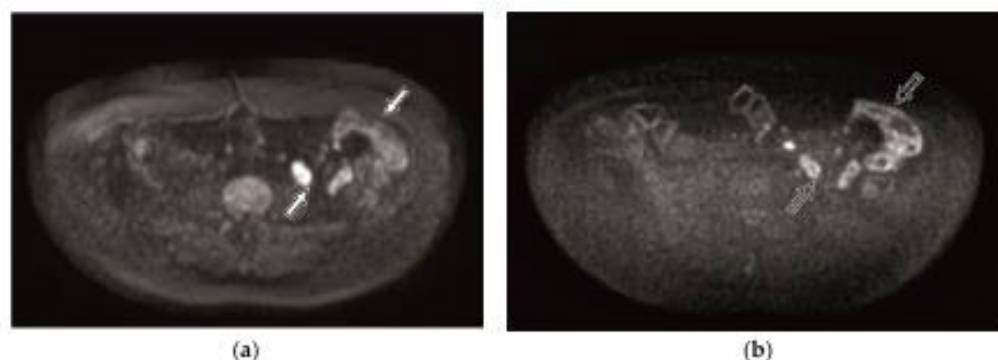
Diffusion-weighted imaging (DWI) (a) and diffusion-weighted imaging with background body signal suppression (DWIBS) (b) tracking images of $b = 800 \text{ s/mm}^2$ within the magnetic resonance enterography (MRE) of 41-year-old female patient with intact bowels. The unaltered bowel wall shows high signal intensity (SI). Better resolution of the bowel loop in the DWIBS image (b, black arrow) is seen comparing to the DWI image (a, white arrow).
